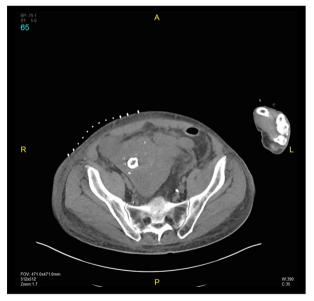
Abdominal computed tomography (CT) imaging at two months following treatment. A CT scan image shows that the abdominal mass was reduced in size after two months of treatment.
